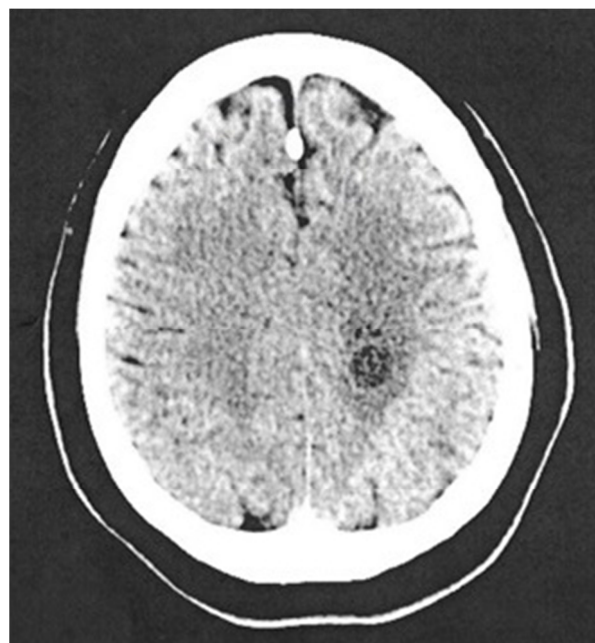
Head CT without contrast: left centrum semiovale round hypodense lesions measures 1.4 cm with perilesional vasogenic edema
